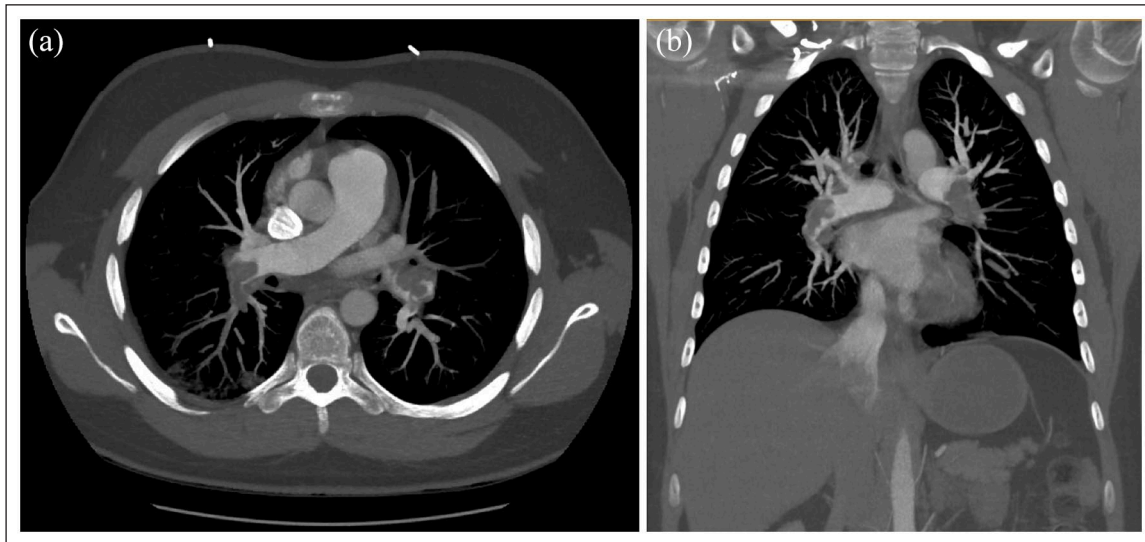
(a) Axial and (b) coronal CTA demonstrating extensive bilateral PE extending into main pulmonary arteries, segmental and subsegmental pulmonary arteries. Also demonstrated is reflux of contrast into IVC and hepatic veins secondary to elevated right heart pressure.
